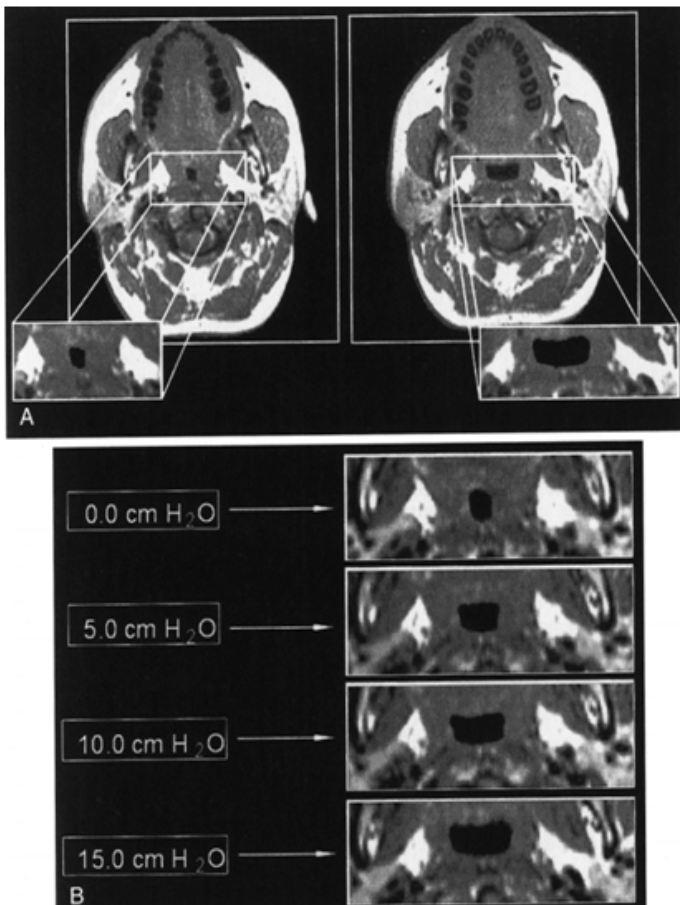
Pre and Post treatment CT of patient treated with CPAP.
